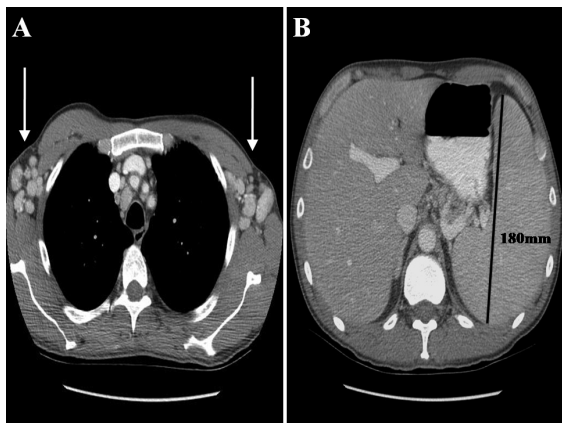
Computed tomographic (CT) scan of the chest and abdomen showing multiple bilateral axillary Lymphadenopathy (A) (white arrows) and splenomegaly (B) at presentation of Multicentric Castleman's disease (MCD).
